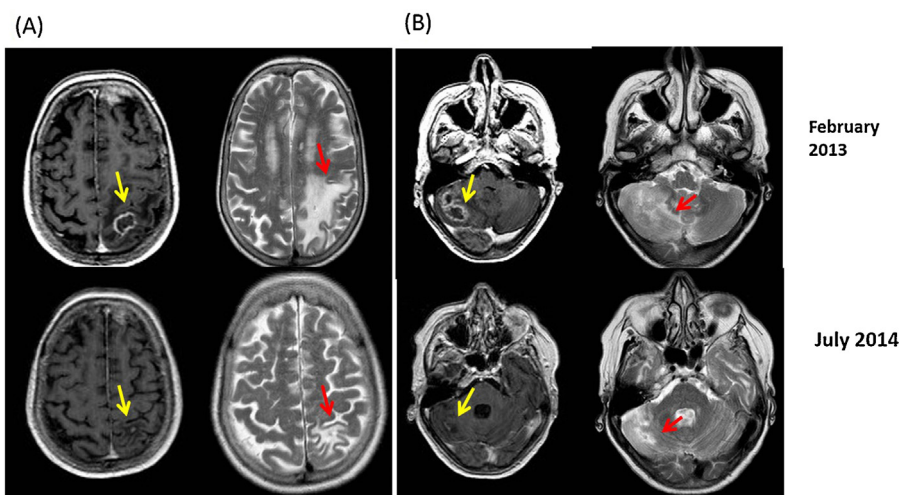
Contrast-enhanced (gadolinium) MRI showing SR of cerebral lesions. MRI in February 2013 demonstrated T1-weighted contrast-enhancing lesion (yellow arrow) in left occipital region (A) and right cerebellar hemisphere (B) with corresponding high signal on T2WI (red arrow). Both lesions had regressed on the MRI scan performed from July 2014.
